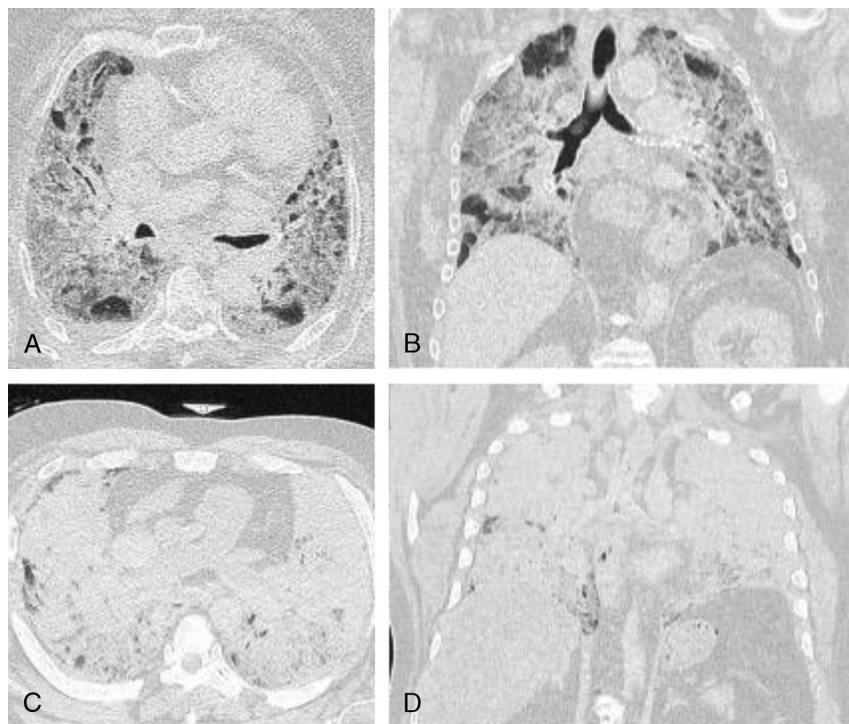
Postmortem computed tomography findings in rapidly fatal community cases of COVID-19. The lung windows of PMCT scans in 2 rapidly fatal COVID-19 cases. Case 2: an 82-year-old woman with a history of essential hypertension who reported severe cough, backache, chest pain, and sore throat before death. Bilateral, ill-defined, mixed densities in a diffuse distribution are demonstrated in the axial plane (A) and in the coronal plane (B). Case 4: a 60-year-old man with uncontrolled diabetes mellitus and chronic ethanol abuse who reported fever, cough, sore throat, dyspnea, and chest discomfort before death. Diffuse consolidations in both lungs are demonstrated in the axial plane (C) and in the coronal plane (D).
